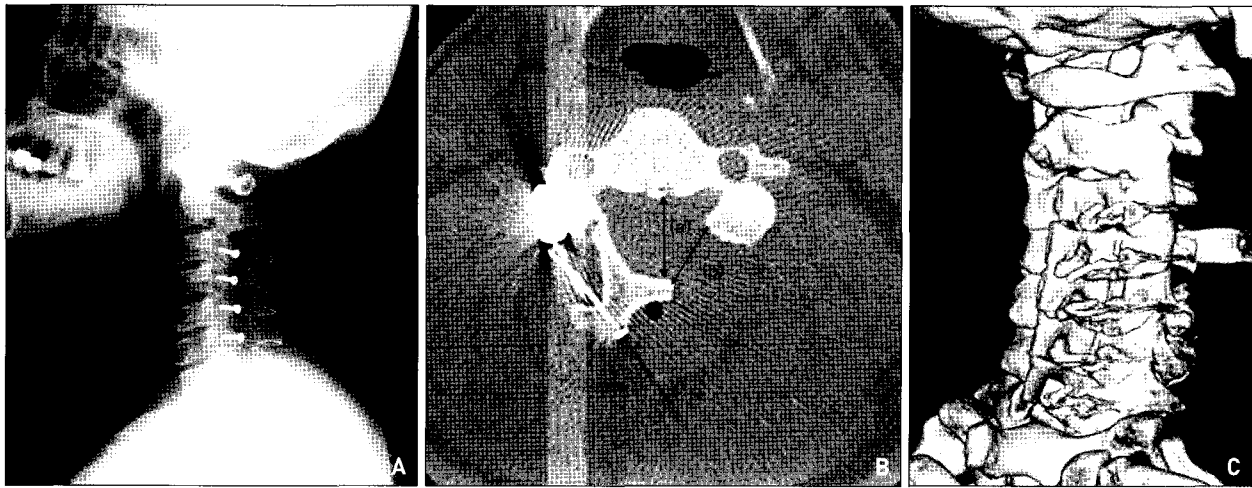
Postoperative image of modified hirabayashi open-door laminoplasty. The wiring and anchoring between the spinous process and lateral mass screw are shown. A : Lateral view of the modified method. B : Computed tomography (CT) axial view of the modified method. a) The anterior-posterior diameter of the cervical canal. b) The gap length of the resected segment. (It is obtained by measuring the shortest distance between the most medial points of the resected laminae to the lateral mass of the open side.) C : Three-dimensional CT scan of the modified method from the final examination.
